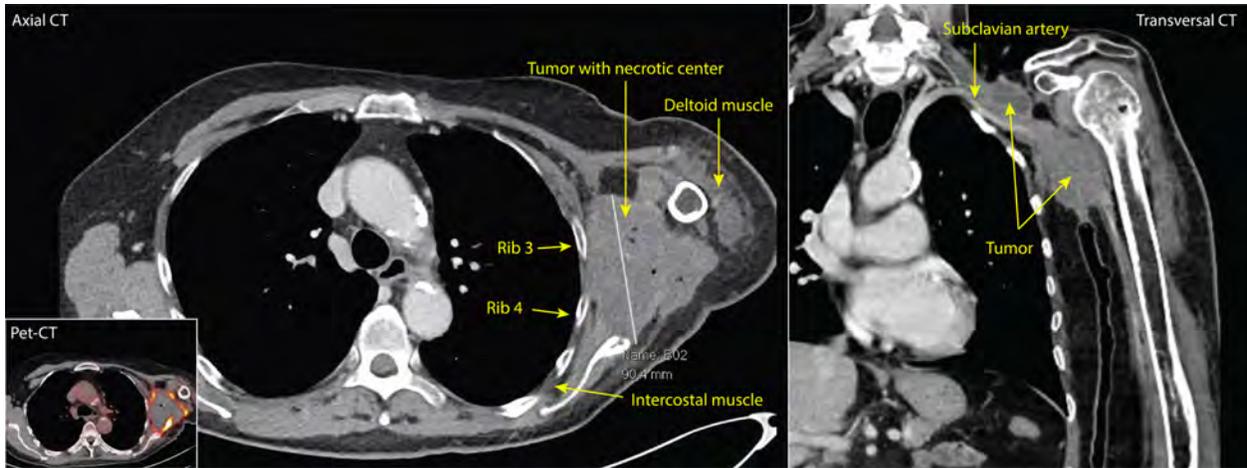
Computed tomography (CT) and positron emission tomography-CT (PET-CT) image of the tumorous process in the left axilla region.
